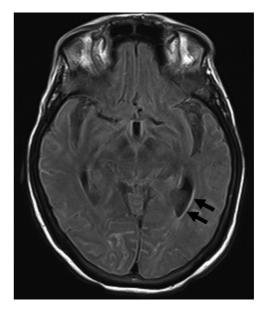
MRI with and without contrast for Case 1. Curvilinear pial/subarachnoid enhancement and T2/FLAIR hyperintensity in the left temporal lobe is shown adjacent to the left posterior horn (black arrows).
